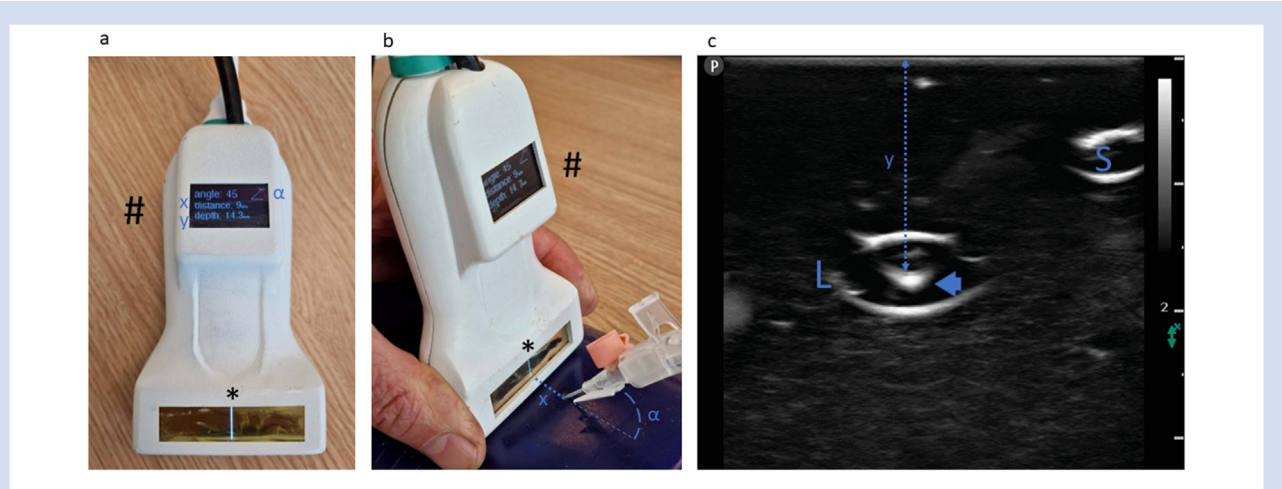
Organic light-emitting diode (OLED)-enhanced probe. (a) The OLED display (#) showing the angle of approach (α) and visual representation of that angle, the suggested distance of the needle entry point to the probe (x), and the depth of the selected target (y). The strip (*) shows the horizontal position of the target relative to the probe. (b) OLED-enhanced probe in action. Optimisation of the needle entry point with suggestions for the horizontal position (*), distance to the probe (x), and angle of approach (α). (c) Ultrasound touch screen with selected large vessel (L) at depth y, with intraluminal needle tip (arrowhead). The small vessel target is also visible in the upper right corner (S).
